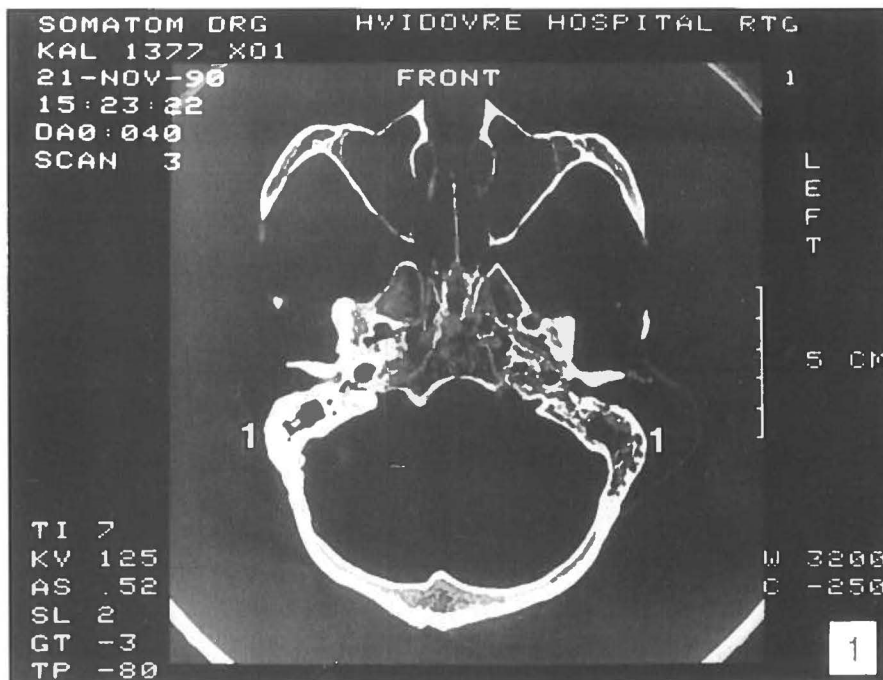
CT-scan at the mastoid level of cranium no. 1. The cell systems on both sides are seen (1).
